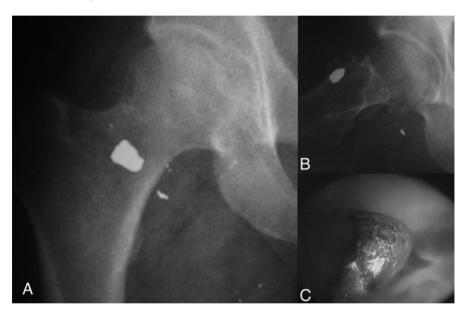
A: Anteroposterior right hip X-ray showing an incarcerated bullet and metal fragments in the peripheral compartment of the anterior neck; B: Cross-leg hip view showing the distal location in the peripheral compartment; C: Intraoperative arthroscopic view showing the metal fragment of the bullet in the medial gout of the peripheral compartment.
